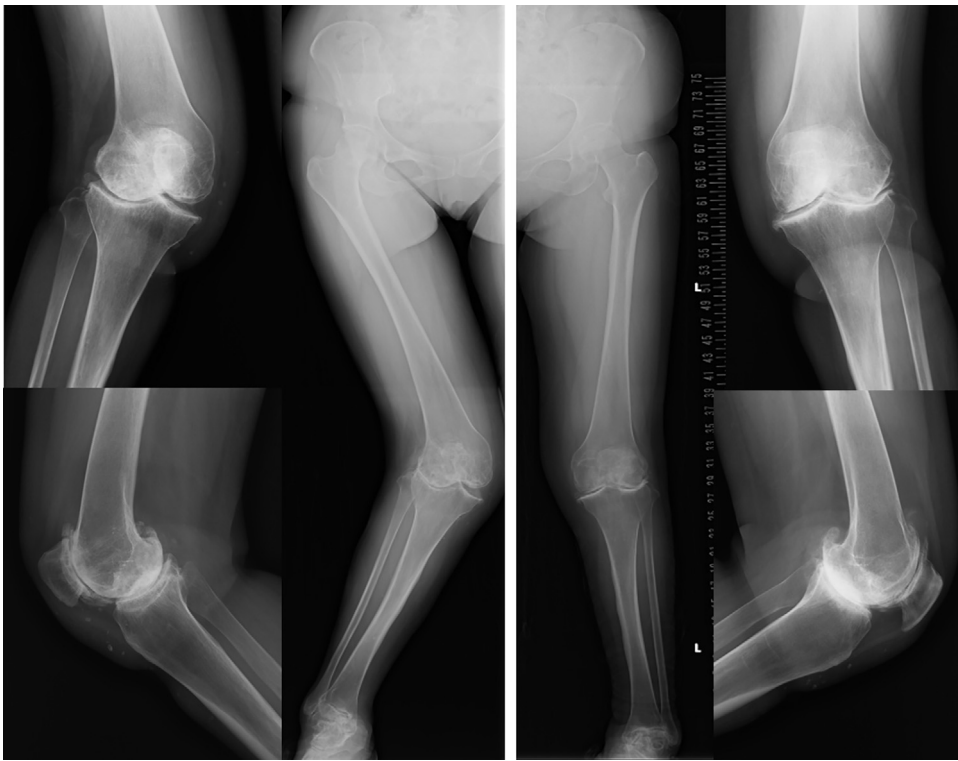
Preoperative radiographs of the knees. The radiographs show bilateral severe valgus knee deformity.
